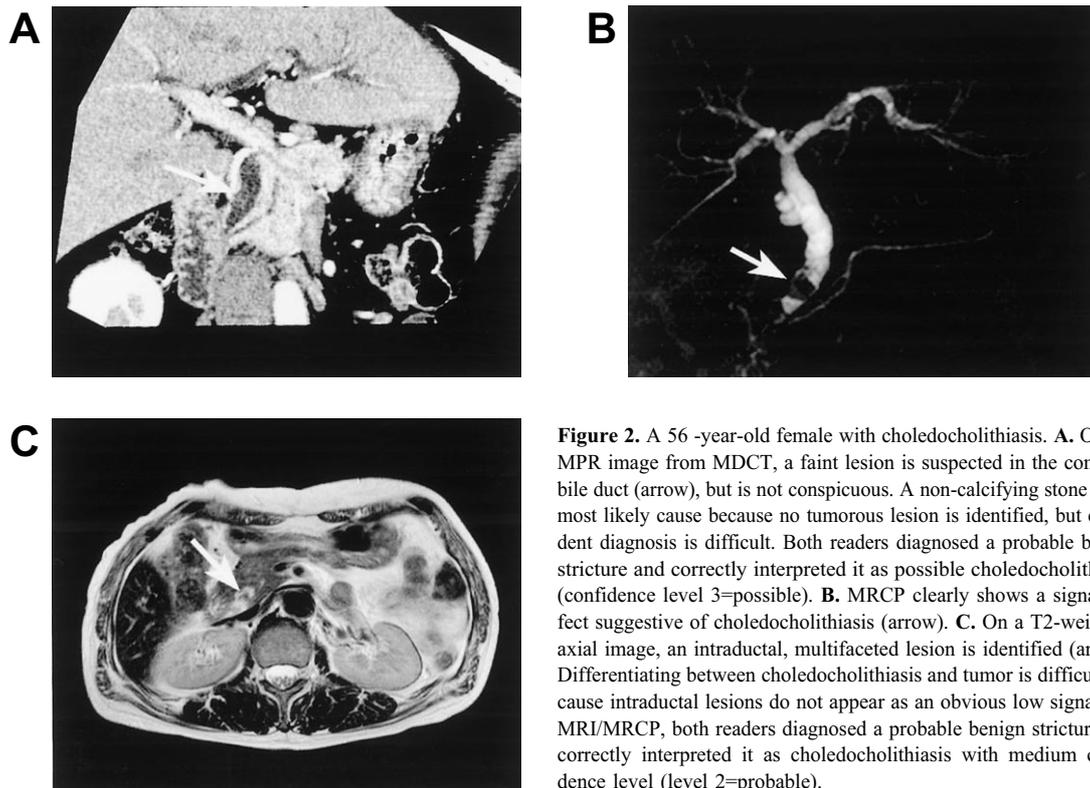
A 56-year-old female with choledocholithiasis. A. On the MPR image from MDCT, a faint lesion is suspected in the common bile duct (arrow), but is not conspicuous. A non-calcifying stone is the most likely cause because no tumorous lesion is identified, but confident diagnosis is difficult. Both readers diagnosed a probable benign stricture and correctly interpreted it as possible choledocholithiasis (confidence level 3=possible). B. MRCP clearly shows a signal defect suggestive of choledocholithiasis (arrow). C. On a T2-weighted axial image, an intraductal, multifaceted lesion is identified (arrow). Differentiating between choledocholithiasis and tumor is difficult because intraductal lesions do not appear as an obvious low signal. On MRI/MRCP, both readers diagnosed a probable benign stricture and correctly interpreted it as choledocholithiasis with medium confidence level (level 2=probable).
